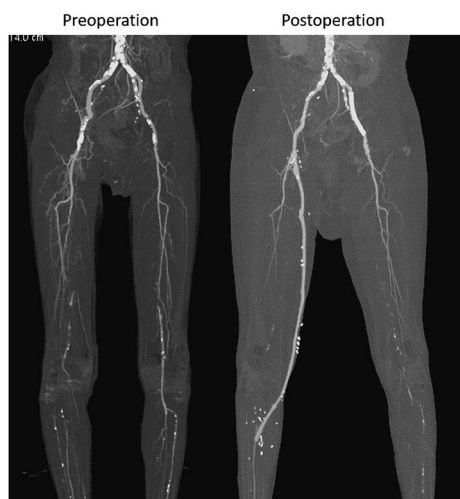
Computed tomography angiography before and after revascularization. The latter was taken after the discontinuation of extracorporeal membrane oxygenation support, showing worse in the left lower leg perfusion.
